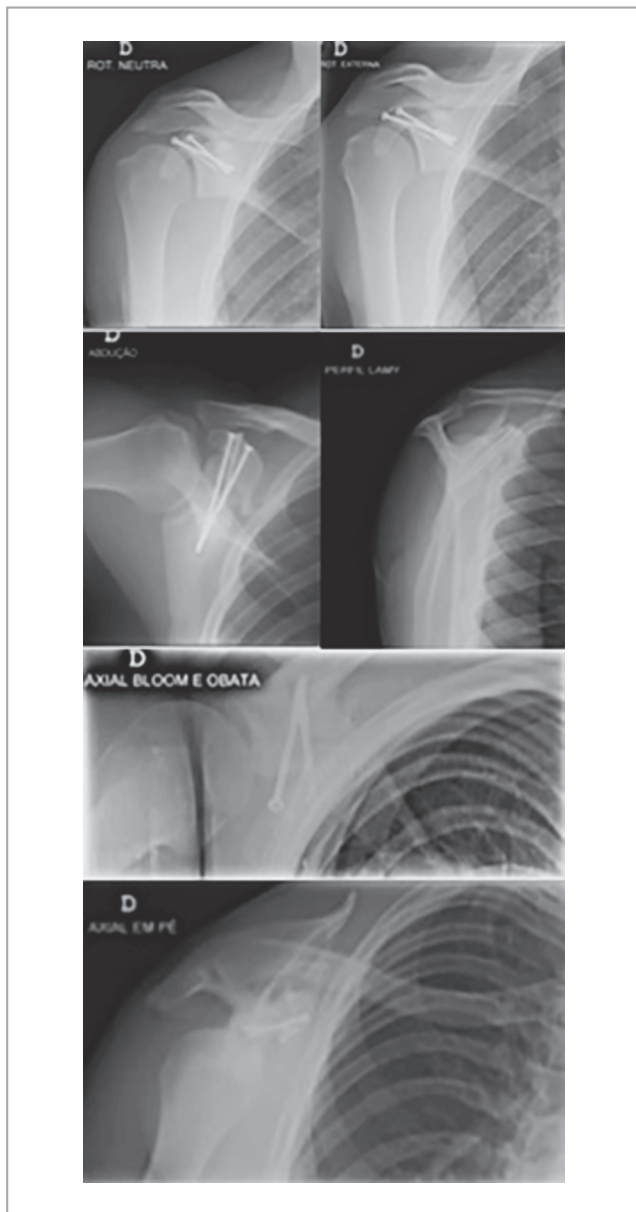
Plain radiography of the injured shoulder 10 weeks after surgery.
